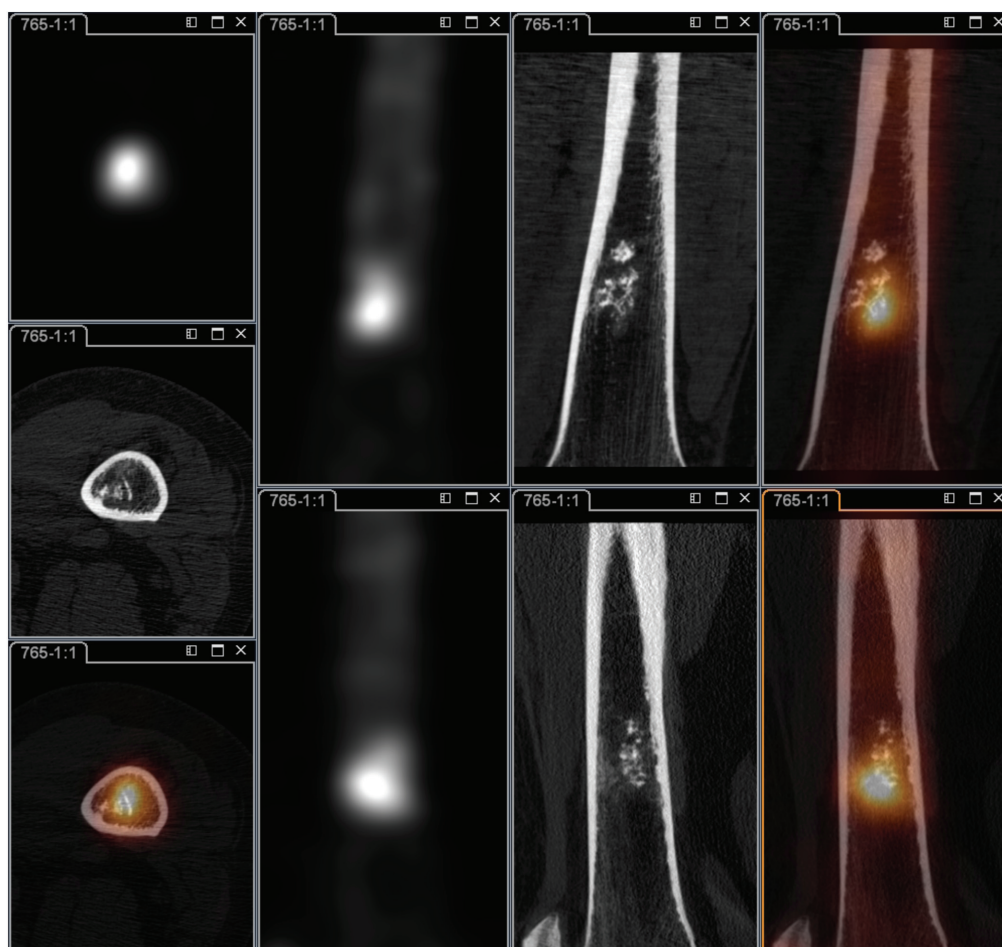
A high-resolution SPECT/CT of the left distal femur shows stippled calcifications within the distal femoral intramedullary cavity without additional aggressive features, which is highly suggestive of enchondroma.
